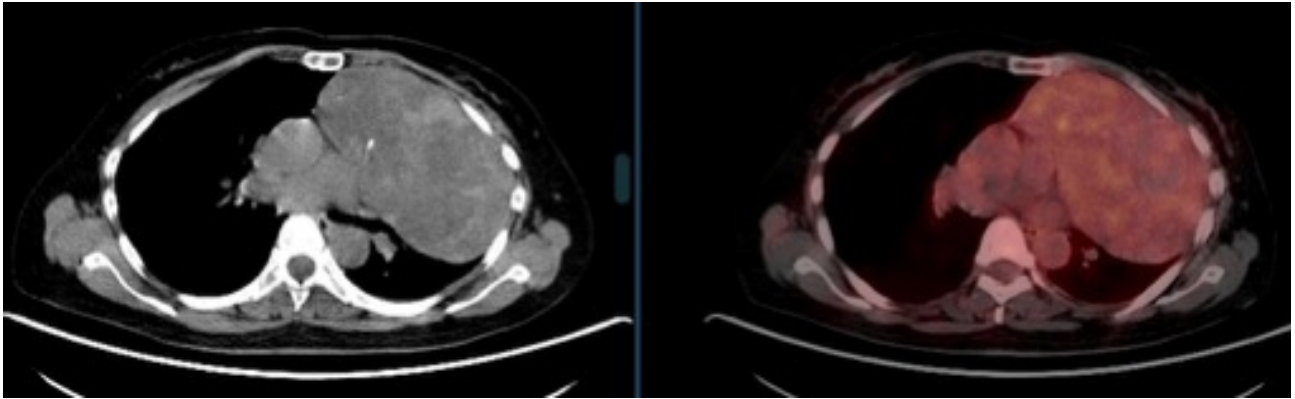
PET/CT images of an anterior mediastinal mass case diagnosed via anterior mediastinotomy.
